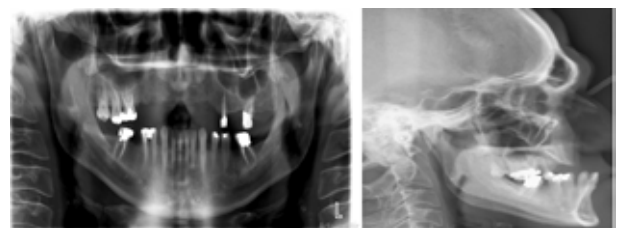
The preoperative radiographs.
